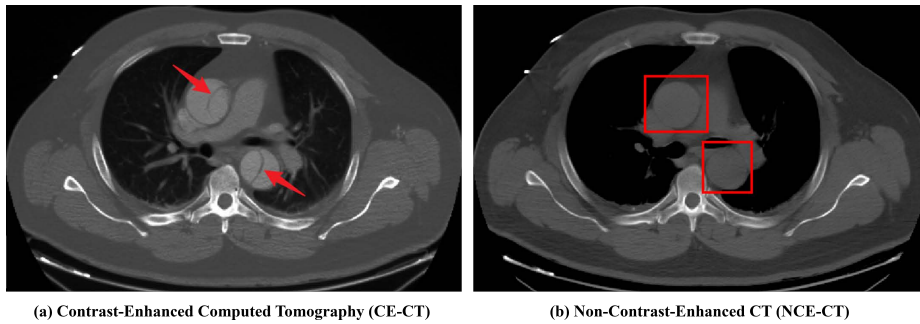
A patient with aortic dissection (AD): The dissection is visible in the CE-CT, but identifying the dissection in the corresponding NCE-CT is challenging.
